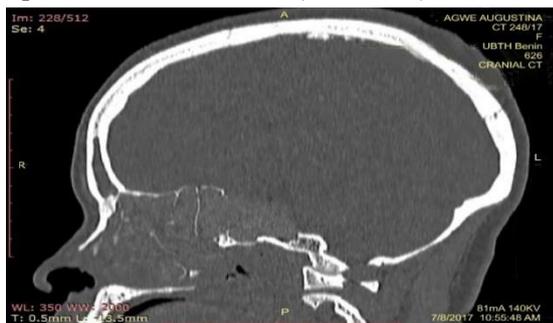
Cranial CT Sagittal section (Bone window) showing complete hyperdense frontal sinuses LMS 2
